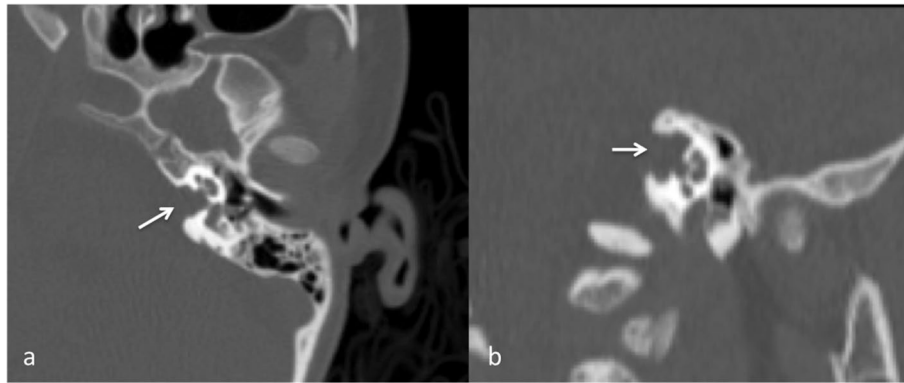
Axial (a) and coronal (b) oblique reformatted CT image shows left IAC (white arrows)
